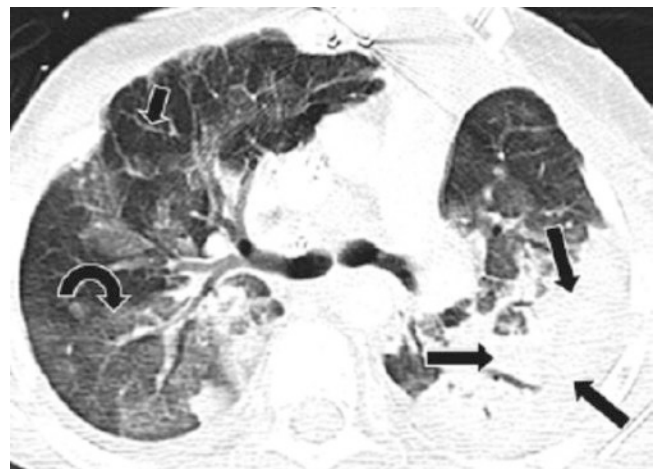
A 15-year-old girl with bilateral lung transplantation for cystic fibrosis. Axial lung window CT image shows ground-glass opacification (*curved arrow*), septal thickening (*short arrow*), and air-space consolidation (*long arrows*) compatible with acute cellular rejection
